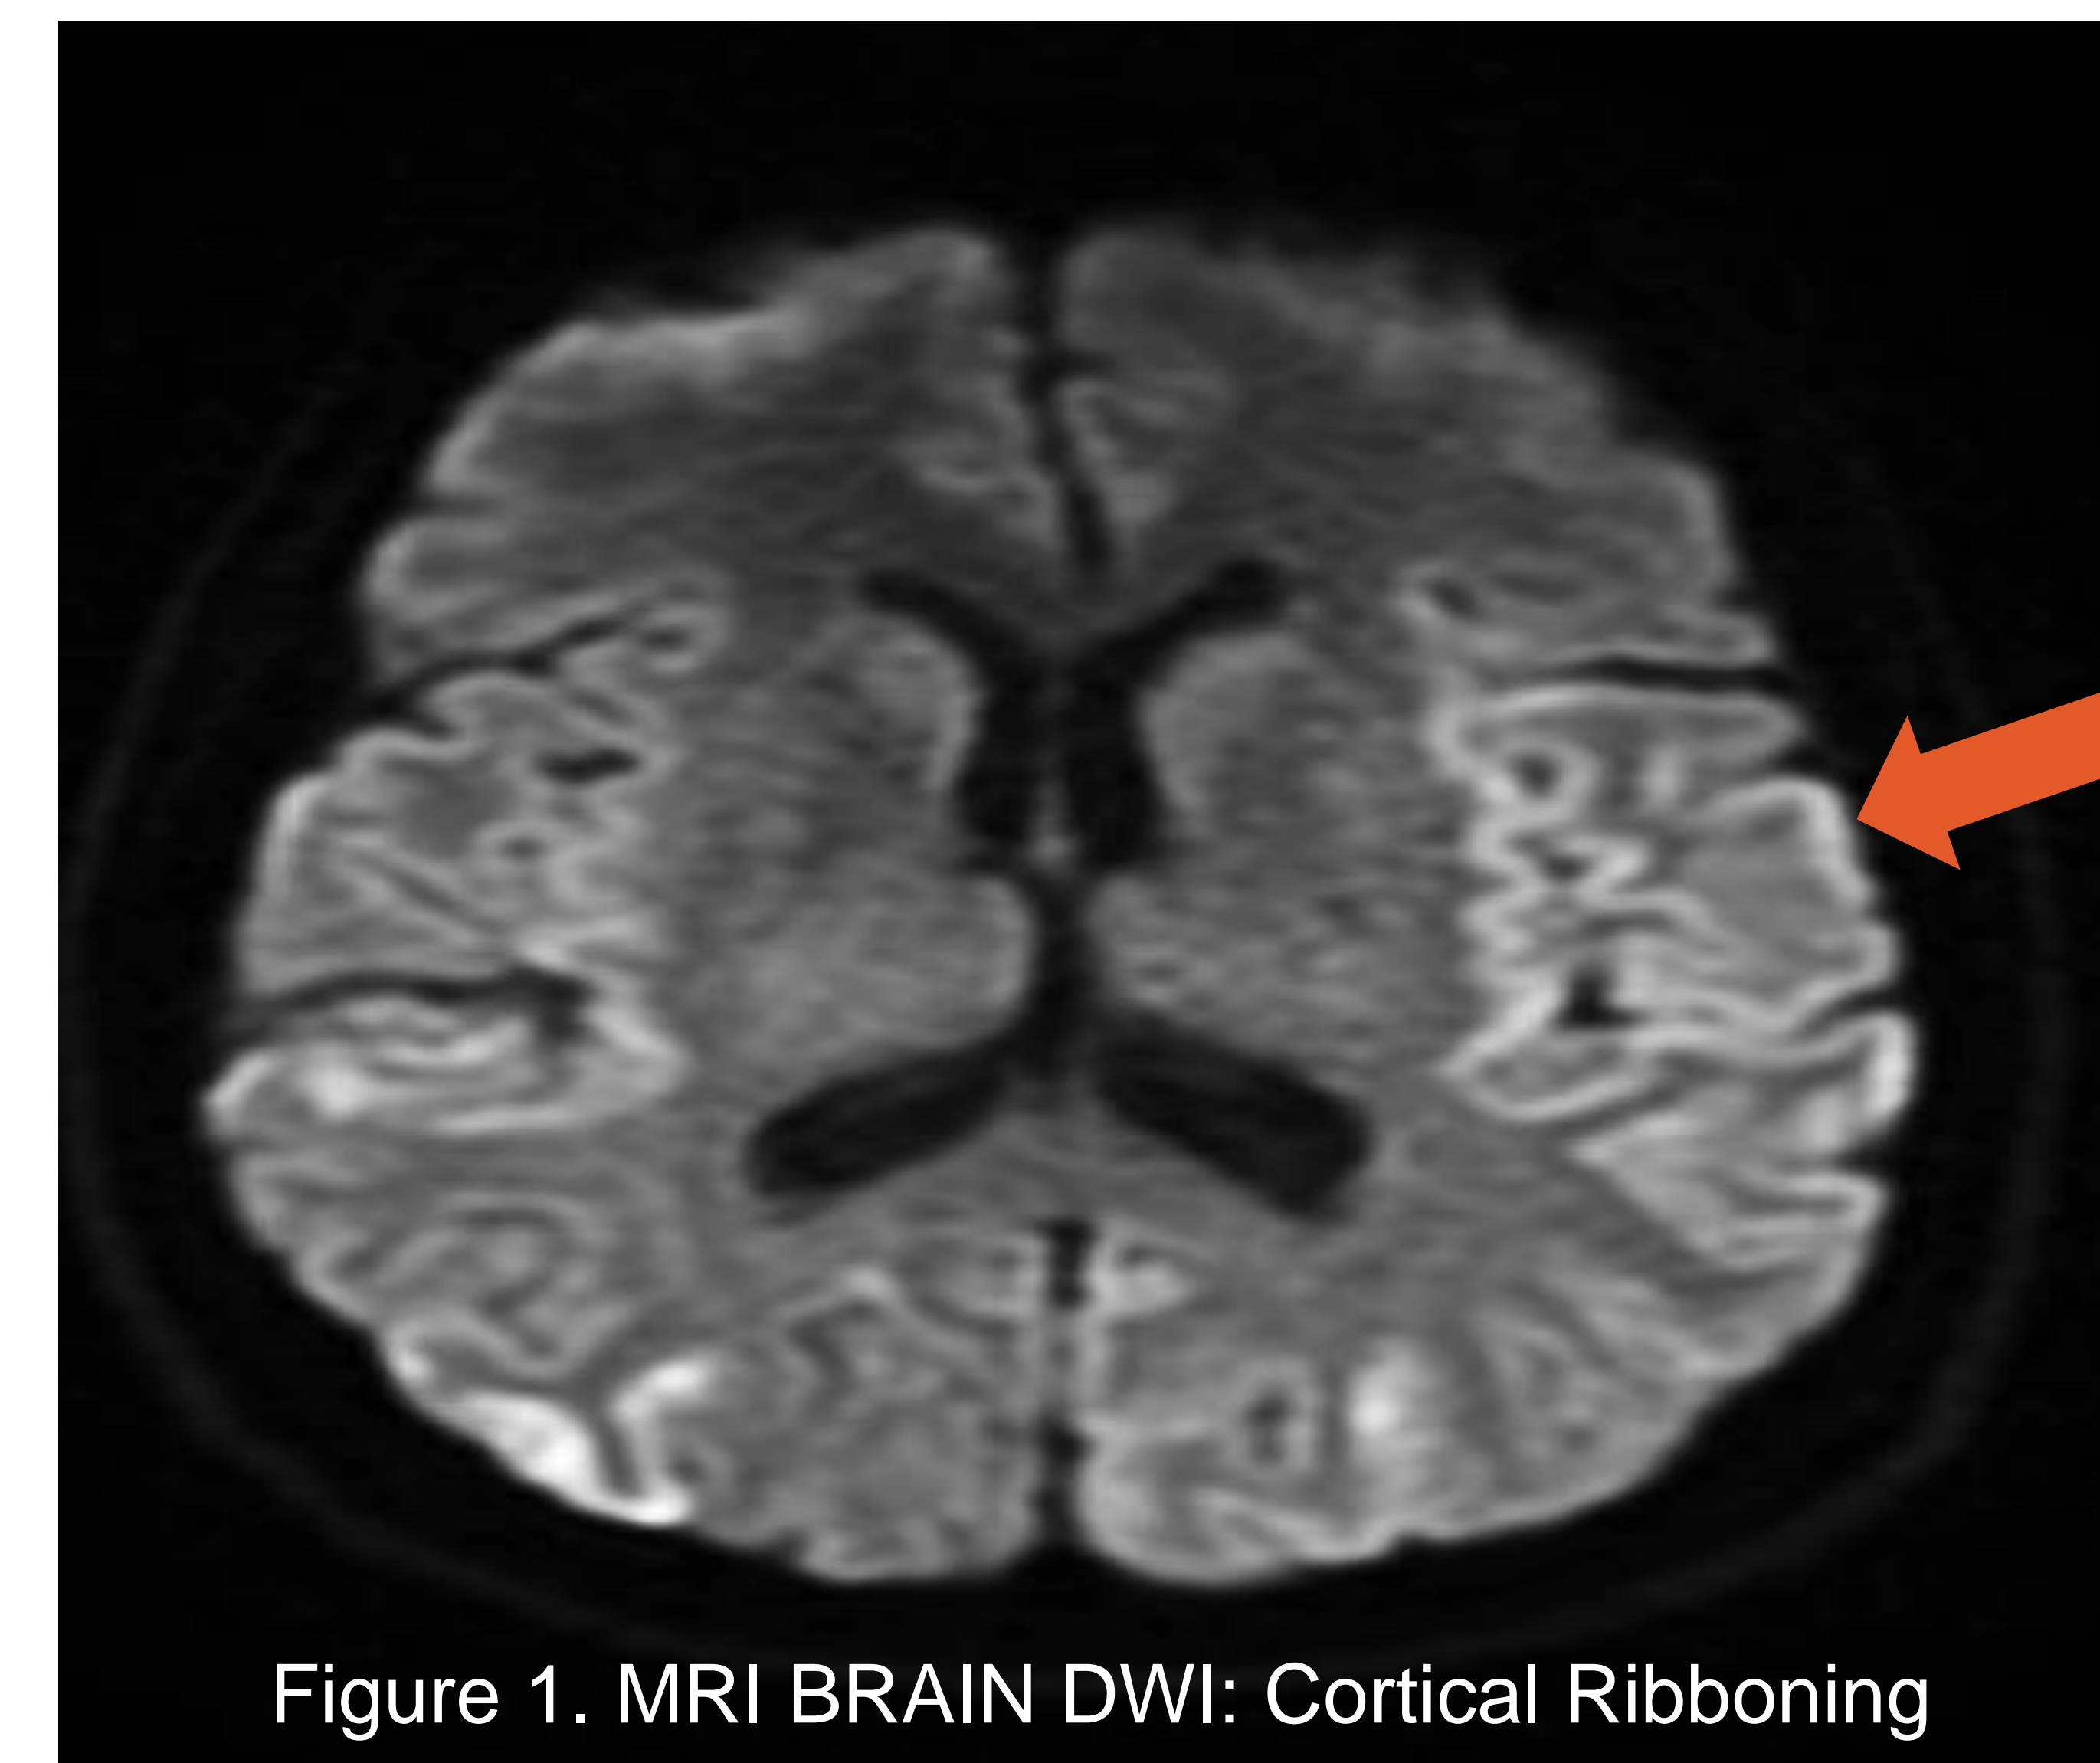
MRI BRAIN DWI: Cortical Ribboning
